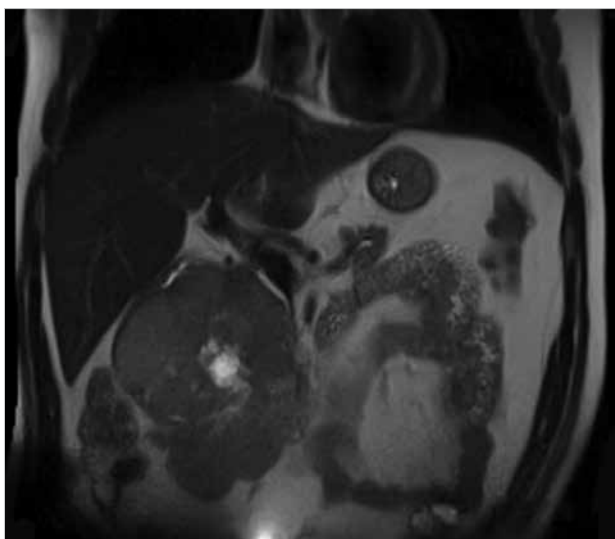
MRI demonstrating the pancreatic mass (coronal view)
